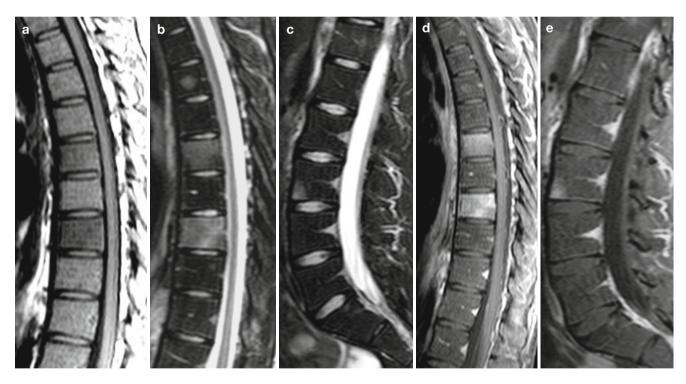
Sagittal TSE T1-weighted image (a), sagittal TSE T2-weighted images with fat saturation (b–c), sagittal SE T1-weighted images with fat saturation following the administration of contrast medium (d–e). These images show low signal (a) and increased signal (b) of T5 and T7 vertebral
